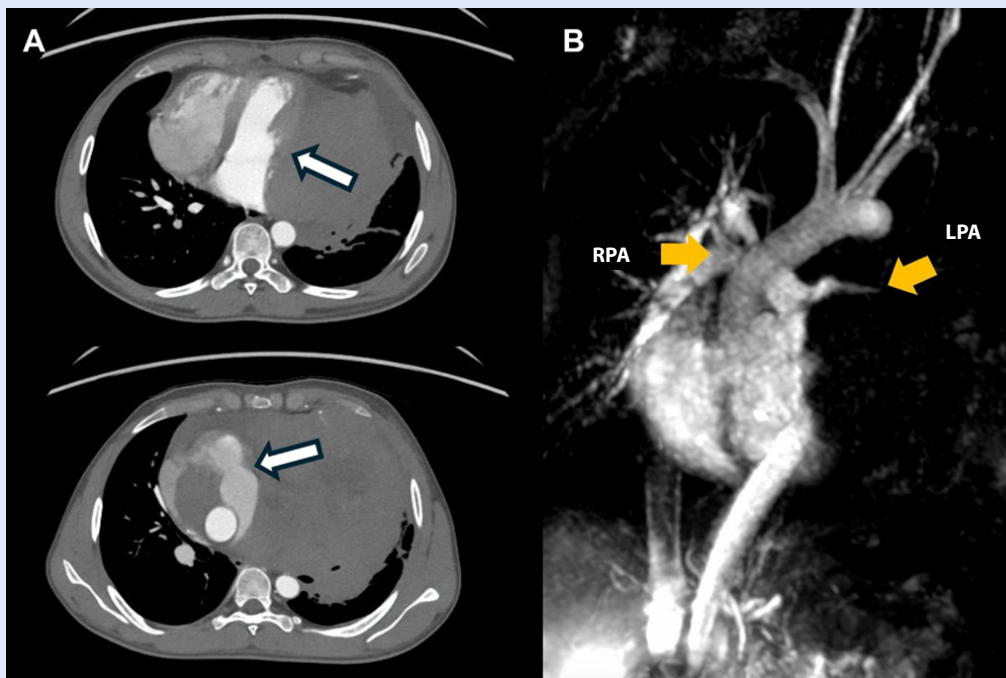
(A) Contrast-enhanced chest computed tomography. In the upper image, the arrow indicates the compressive effect on the left-sided cardiac chambers and their displacement towards the contralateral hemithorax; in the lower image, the arrow indicates narrowing of the main pulmonary artery, producing an obstructive effect with increased velocities and gradients on ultrasound. (B) Thoracic magnetic resonance imaging showing collapse of the left pulmonary artery branch.
